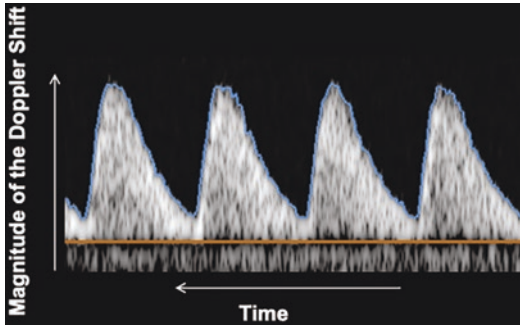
Spectral Doppler waveform from the umbilical arteries. Vertical axis represents the magnitude of the Doppler frequency shift. Horizontal axis represents time. Brightness of the tracing indicates the amplitude of the Doppler spectrum. Note that the recording is scrolled from right to left as new information is continuously added to the right end of the spectral display
